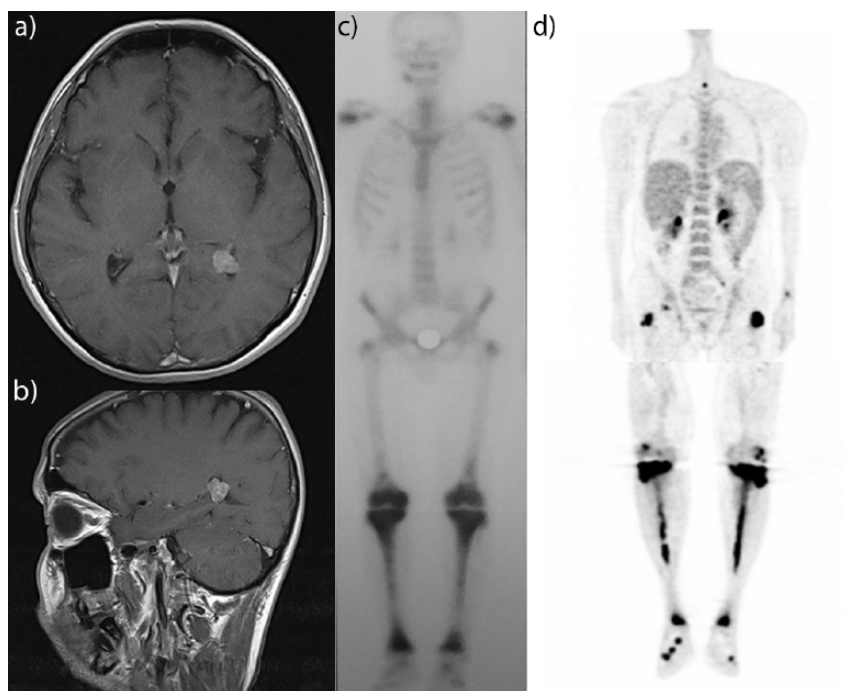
Axial (a) and sagittal (b) T1-weighted MRI of the brain showing a soft-tissue lesion at the choroid plexus of the left lateral cerebral ventricle in a patient with ECD. Bone scan (c) and PET-CT (d) show symmetrically increased uptake at the humeral heads, greater trochanters, knees, tibiae and small bones of the feet in a patient with ECD.
